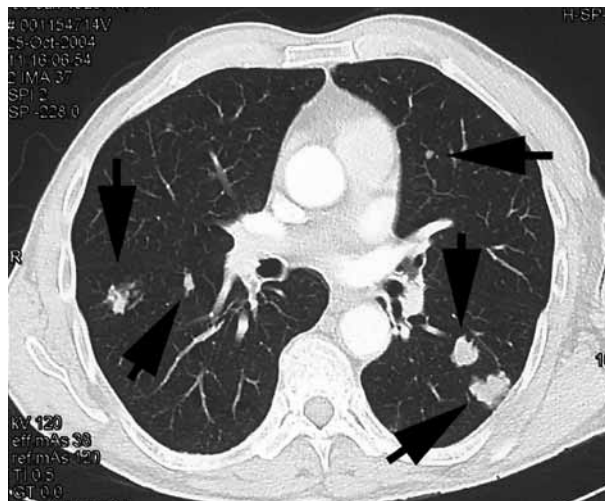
Computed tomography of the chest (case 3) showing pulmonary *E. multilocaris* metastases.
